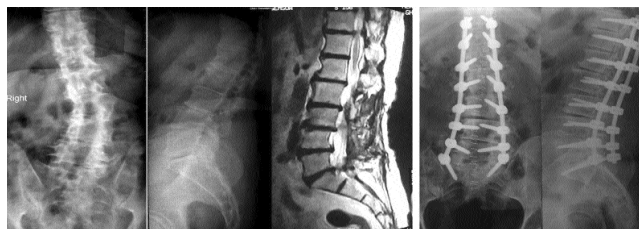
Preoperative and post operative radiographs and magnetic resonance imaging (MRI) scan. Marked correction was achieved after pedicle instrumentation.
